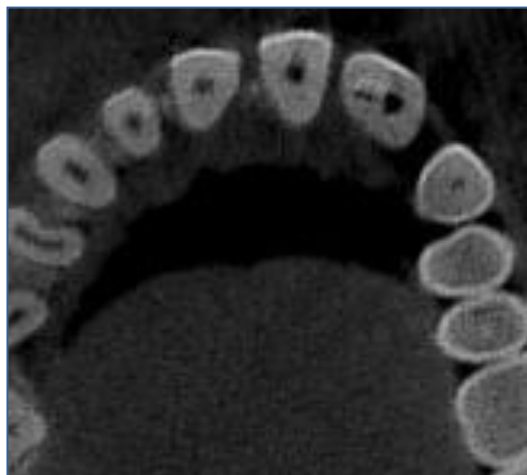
CBCT showing dens invaginatus Type IIIb with Periapical lesion.
